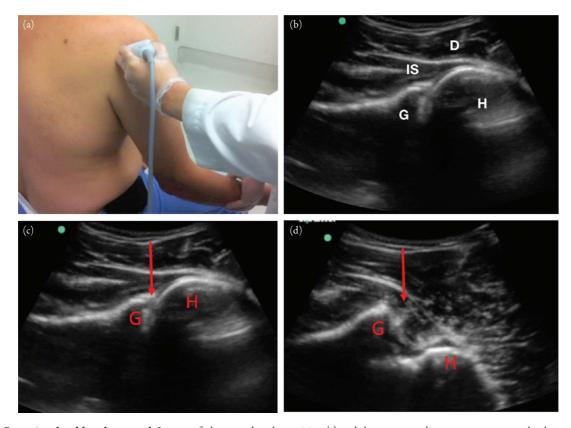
Posterior shoulder ultrasound. Images of ultrasound probe position (a) and the corresponding transverse grayscale ultrasound image (b) of the posterior shoulder. The transducer is positioned in a transverse position just inferior to the scapular spine. In this posterior image of the shoulder (b) the structures closest to the probe, at the superior aspect of the image, are located more posteriorly in the body. The structures farthest from the probe, at the inferior aspect of the sonographic image, are located more anteriorly in the body. The deltoid muscle (D) is seen superficially, with the infraspinatus muscle and tendon (IS) just deep to it. The IS attaches to the greater tuberosity of the humeral head (H). It can be seen contracting with external rotation of the shoulder. The gleno-humeral joint is formed by the humeral head and the glenoid rim (G). In a normal shoulder (c), the posterior cortex of the humeral head is more posterior (arrow) than the glenoid. In an anterior shoulder dislocation (d), the humeral head (H) is displaced anteriorly (arrow) compared to the glenoid (G). This places the humeral head (H) farther from the probe and more inferior on the sonographic image compared to the normal shoulder (c).
